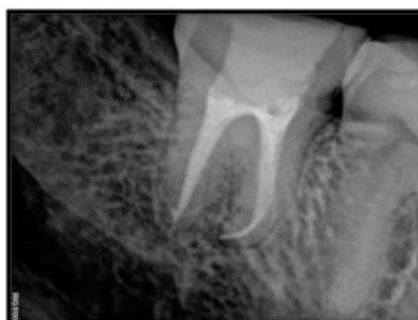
Radiograph taken 1-year after treatment indicating a successful outcome.
